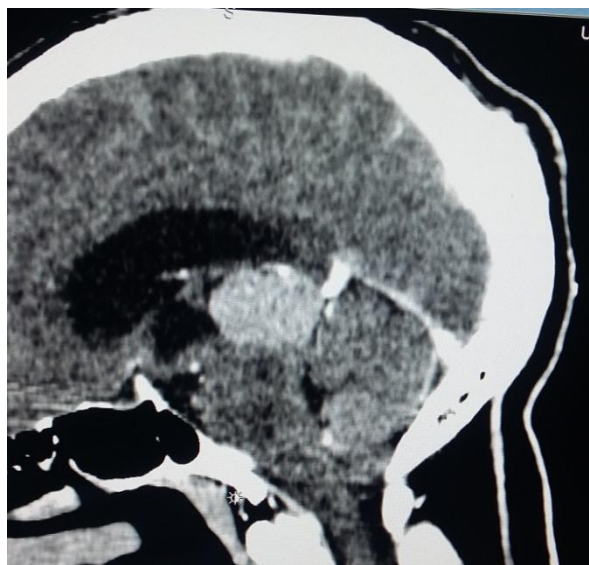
Contrast enhanced CT of the brain showing an avidly enhancing mass intracranial mass in the region of the pineal gland associated dilation of the lateral and third ventricles.
